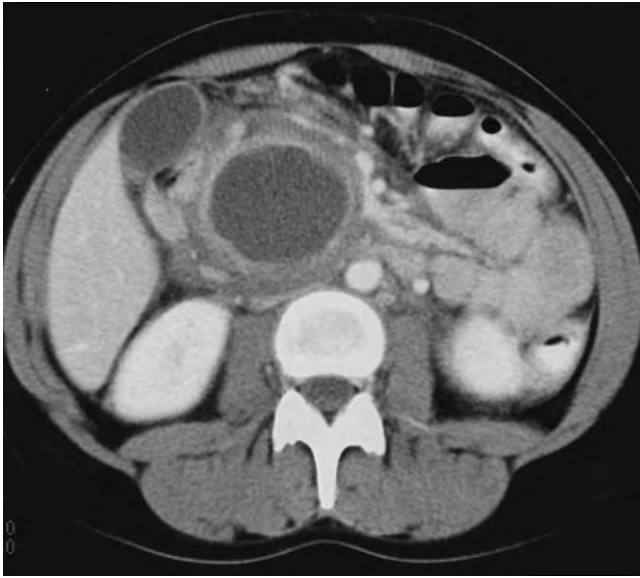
Computed tomography scan of a patient with a pancreatic pseudocyst in the head of the pancreas. The patient had symptoms of abdominal pain and nausea. The gallbladder appears distended, although the results of liver function tests were normal.
